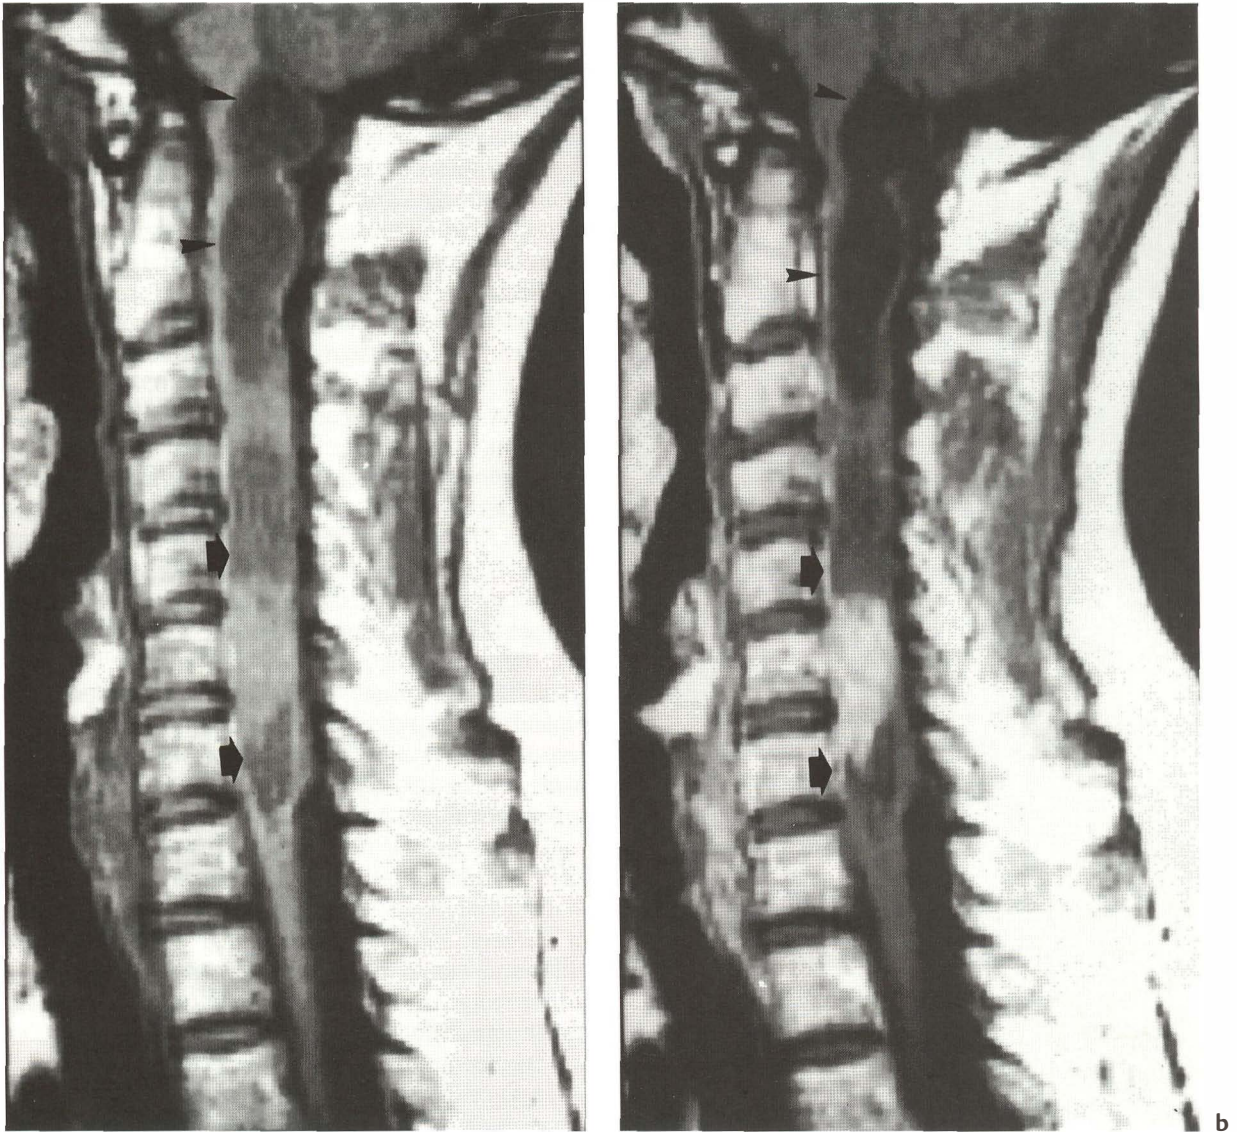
Grade II ependymoma (case 30; same case as in Fig. 71). a Sagittal precontrast, b postcontrast T1-weighted images, and c T2-weighted image. A well-delineated solid mass is seen at C6, which is isointense compared to the cord on both T1-weighted and T2-weighted images. There is intense homogeneous enhancement after contrast administration. Polar cysts (short arrows in a and b) are found at both ends of the tumor. Their signal behavior is different from that of the cerebrospinal fluid, due to a high level of protein within the cystic fluid. The "cap" sign is seen at the caudal tumor margin (long arrow in c). There are brain stem and hydrosyringomyelic cysts (arrowheads in b), with signal behavior identical to that of the cerebrospinal fluid. Note the "straight" appearance of the cervical spine
